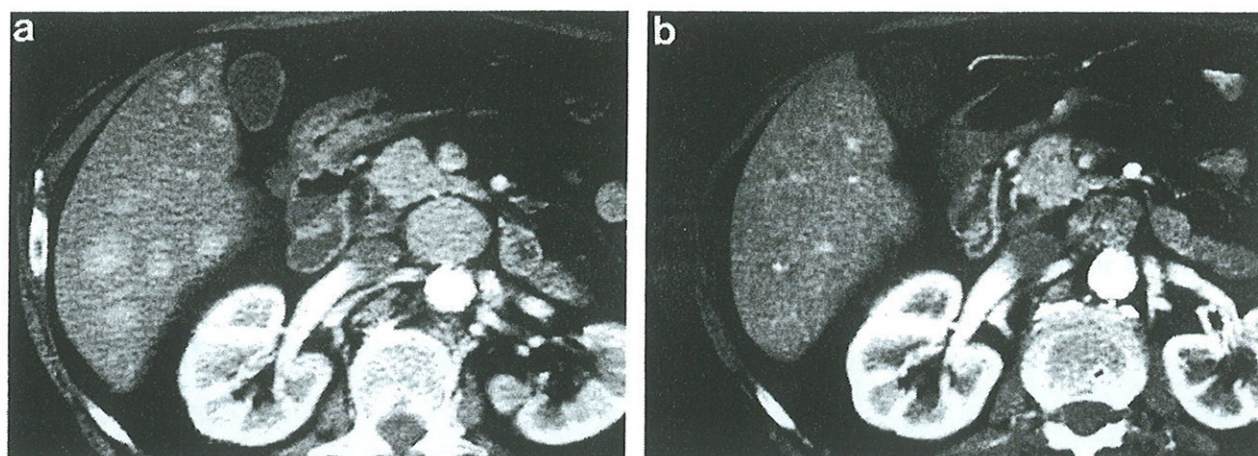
(a) Spiral CT scan during arterial phase performed prior to treatment shows several hypervascularized nodules of HCC in the right lobe. (b) Spiral CT scan performed 6 months after treatment shows the disappearance of the neoplastic hypervascularization inside the nodules. The pattern lasted for 12 months.
